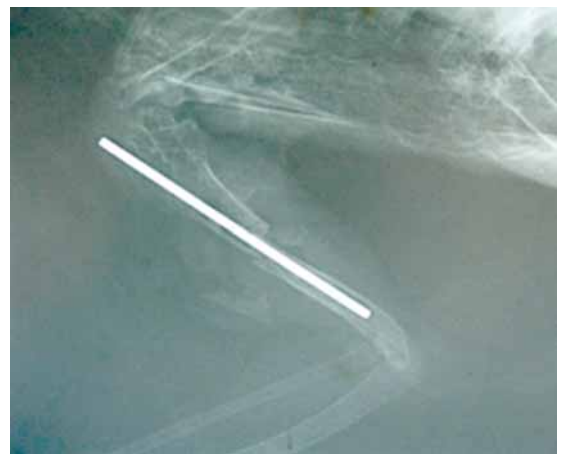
Radiographic check showing proper reduction
